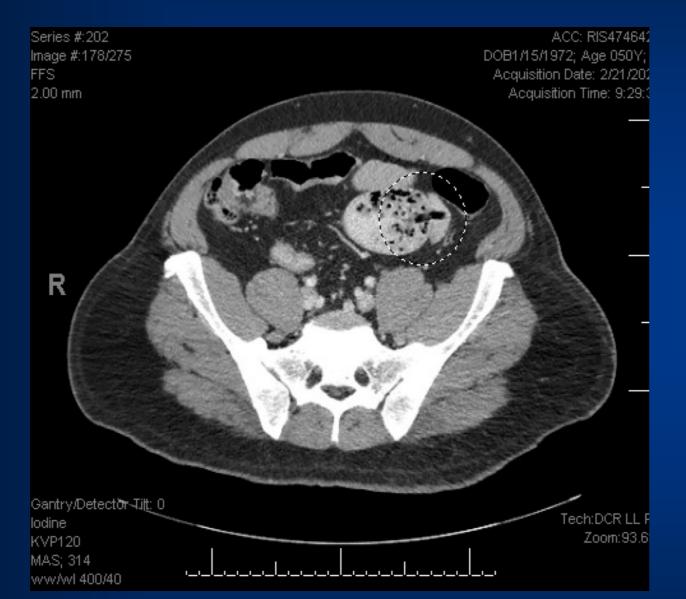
CT abdomen and pelvis with contrast demonstrated multifocal strictures throughout the small bowel.
